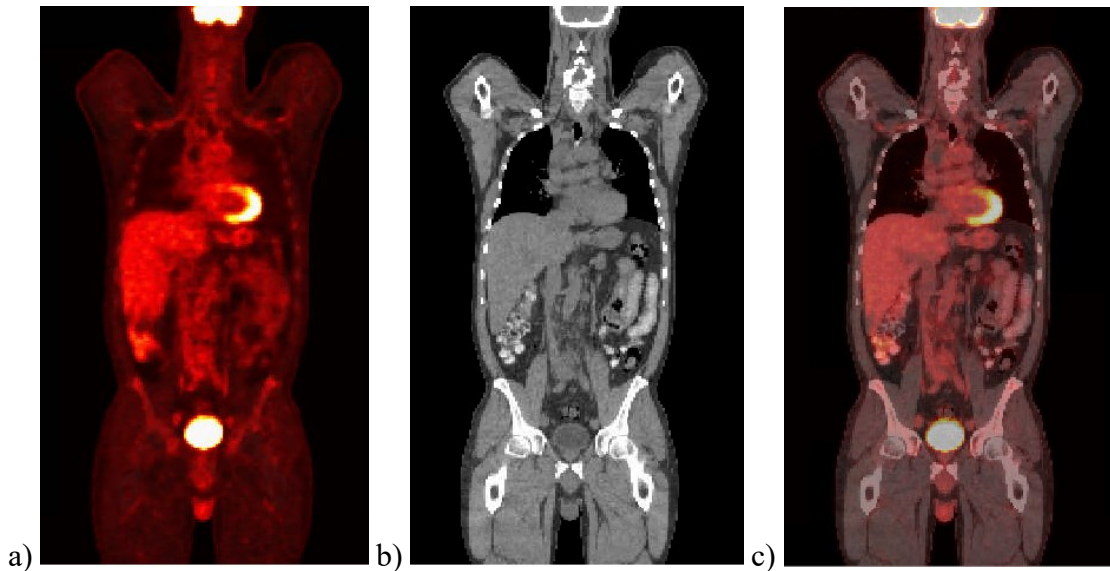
Patient images in the format of a) PET, b) CT, and c) co-registered PET/CT.
